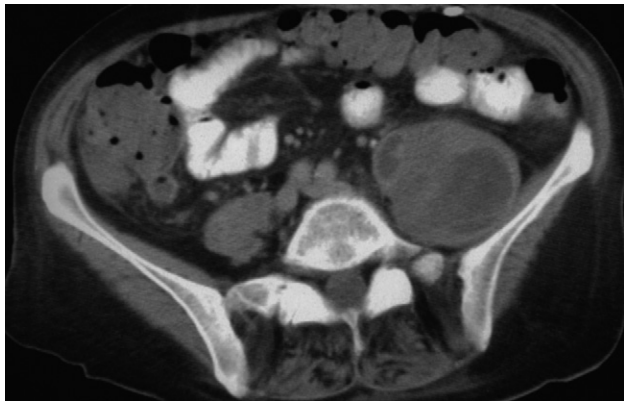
CT scan of a large haematoma in the left iliopsoas muscle. Note the variable density, much of which is of lower density than the normal muscles.
